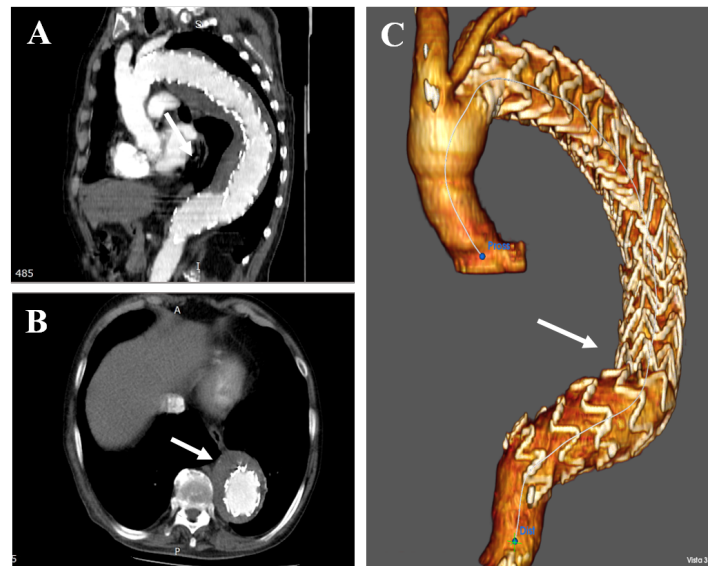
CT-scan at six-month follow-up. A-B: Multi-Planar Reconstruction; C: 3D-Reconstruction. The arrows show optimal endograft placement and endoleak regression.
